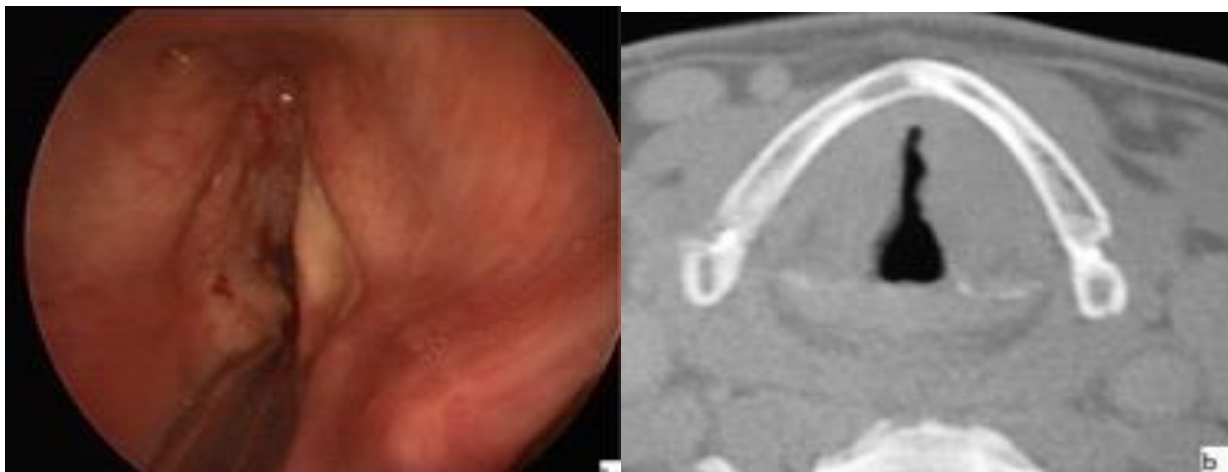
a-Direct laryngoscopy: ulcerated tumor of the left CV with CA involvement and conserved mobility. b- CT scan: Irregular hypodense lesion of the right vocal cord with thickening of the anterior commissure.
